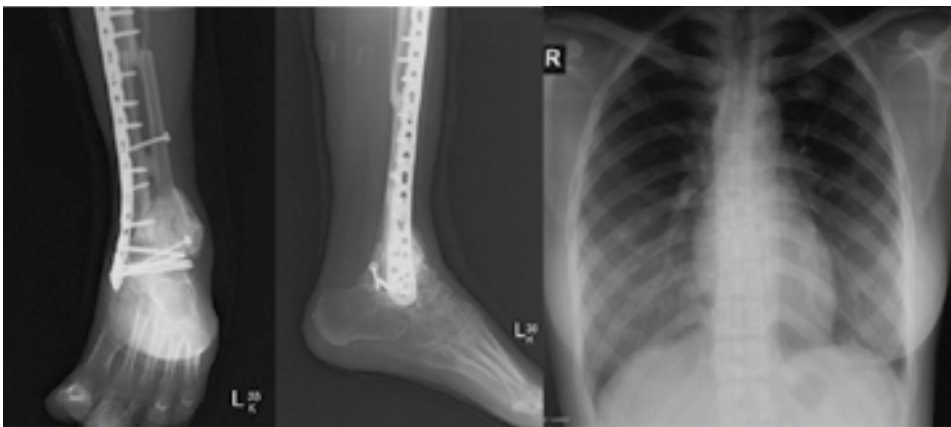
Chest and ankle X-Ray post-surgical bone graft and bisphosphonate therapy
